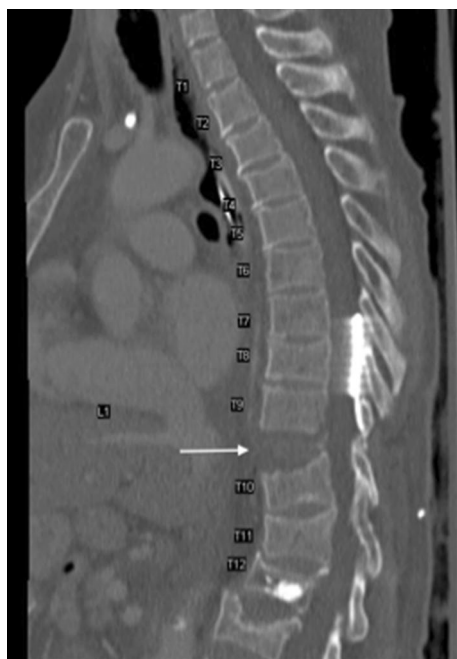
Preoperative sagittal CT of the thoracic spine showing a displaced superior endplate fracture of the T10 vertebral body with marked asymmetric widening of the anterior T9–T10 disk space
